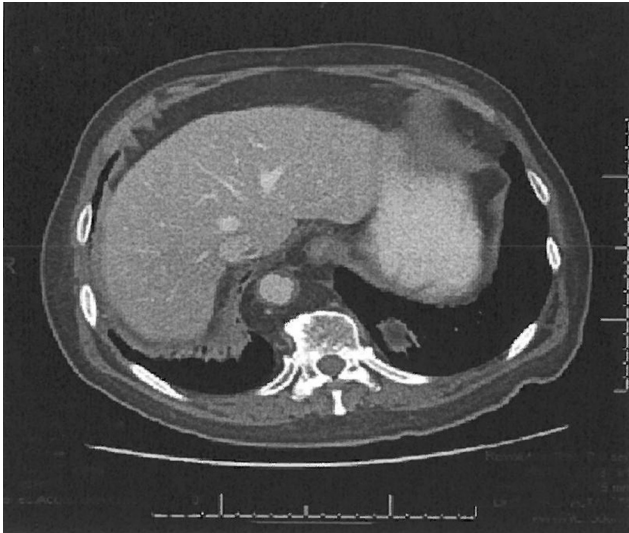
Case 4: most recent CT scan.
